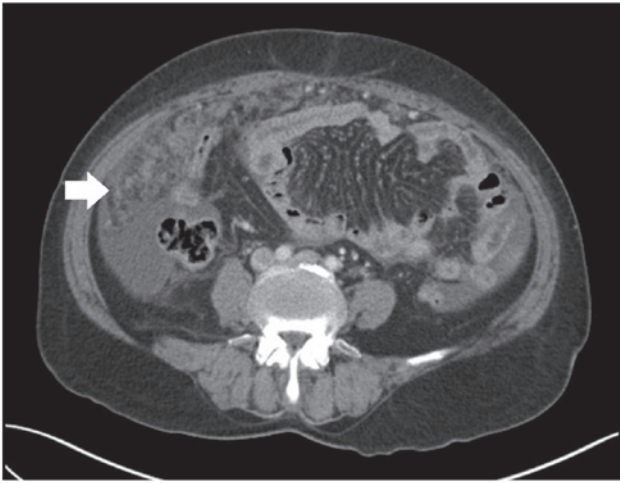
Computed tomography scan revealing abundant ascites and omental infiltration. The white arrow indicates omental infiltration.
